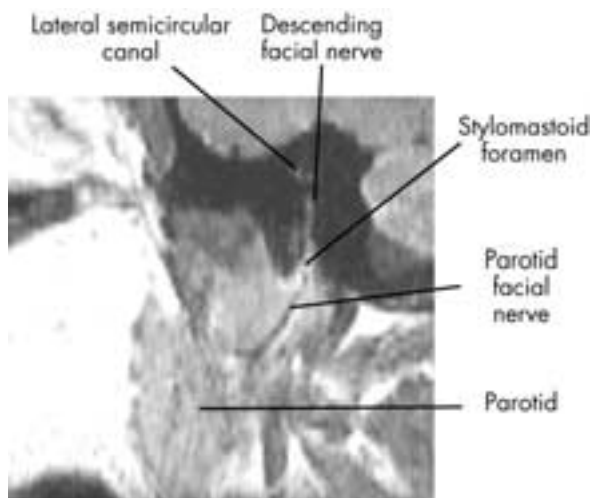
Sagittal MR imaging, descending facial nerve level. At the posterior genu, the facial nerve turns inferiorly, exiting the temporal bone through the stylomastoid foramen.
